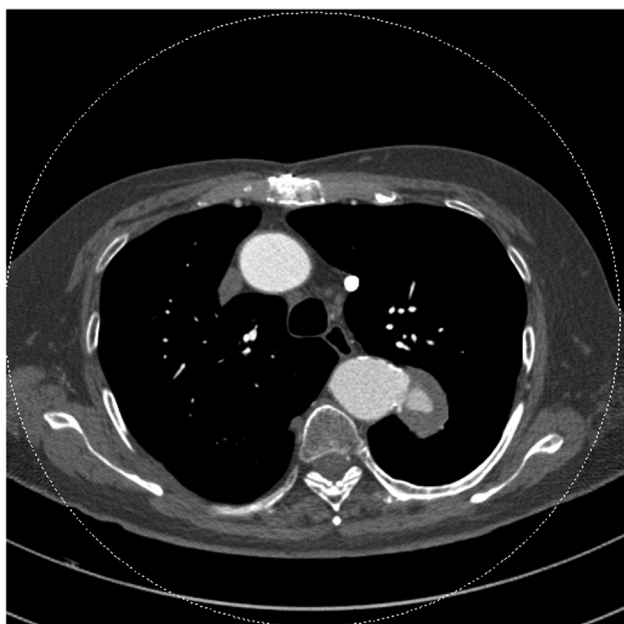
Axial reconstruction of preoperative computed tomography (CT) scan.
